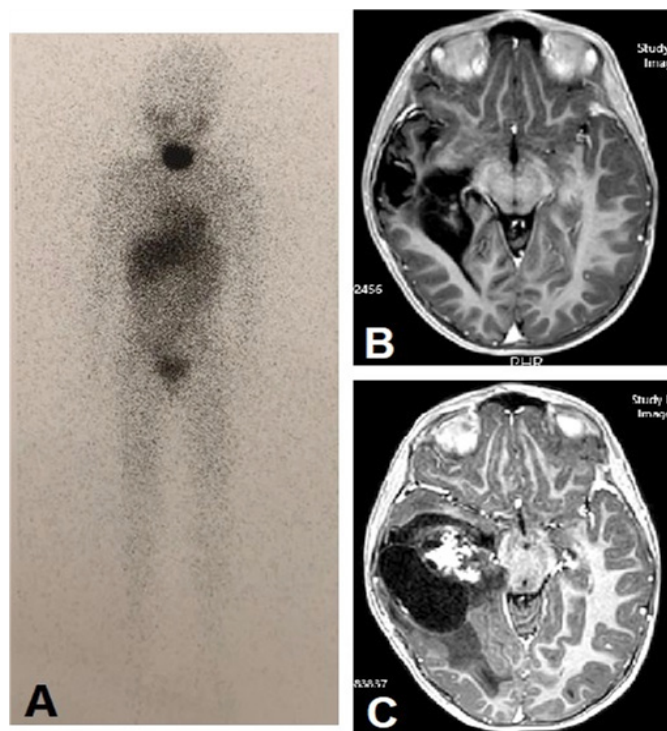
(A) Postoperative nuclear scan using iodine-131 meta-iodobenzylguanidine (MIBG scan) demonstrated normal radiotracer uptake throughout the body. (B) Postoperative brain MRI showed no tumor remnant. (C) Brain tumor recurrence was detected on follow-up MRI one year after surgery.
